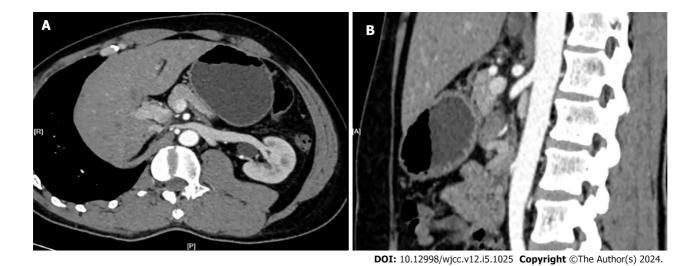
Computed tomography urography of the patient. A: Transverse plane; B: Sagittal plane.
